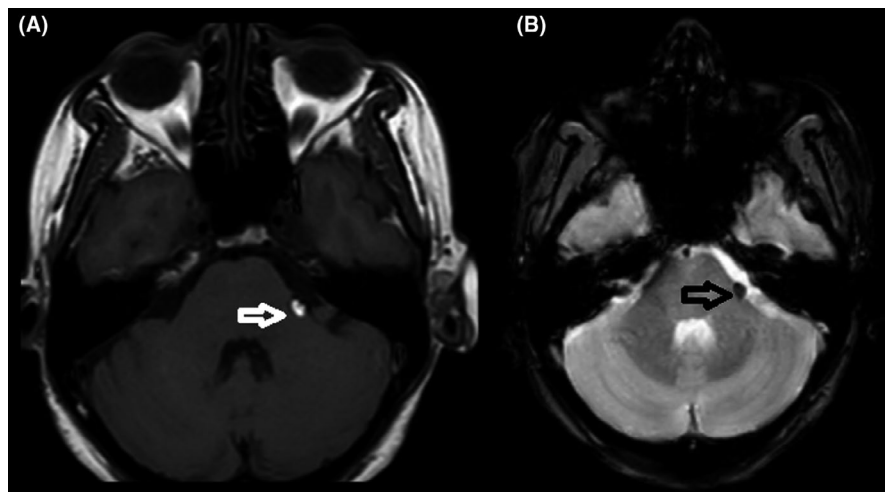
Initial axial MRI series demonstrating a hyperintense lesion on T1- (A) and hypointense on fat suppression sequences (B)
